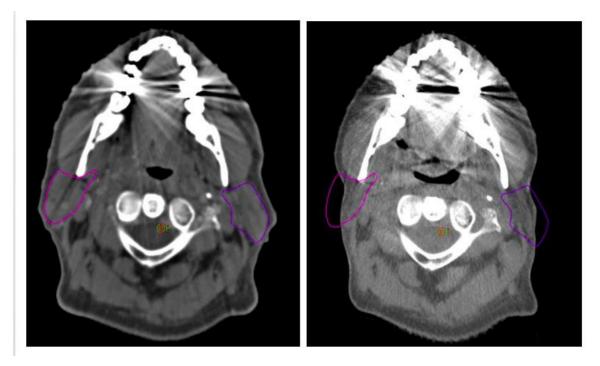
Parotid glands before starting radiotherapy treatment, in the planning CT (left). Parotid glands after significant patient weight loss and after receiving radiation (right).
